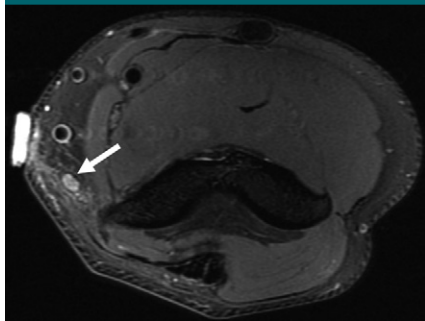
Axial intermediate-weighted FS MR image in an 18-year-old male water polo player, who had recurrent symptoms of ulnar neuritis following anterior transposition of the ulnar nerve, including pain, numbness, and tingling in his fourth and fifth digits. Increased signal intensity is seen within the transposed ulnar nerve (arrow). At electromyography there was decreased recruitment and isolated denervation of the flexor digitorum profundus, first dorsal interosseous, and abductor digiti minimi muscles, consistent with acute ulnar neuropathy. Subsequent surgery found scarring in both the ligament of Struthers and the fascial sling, and the patient's symptoms abated after the transposed nerve was released.
